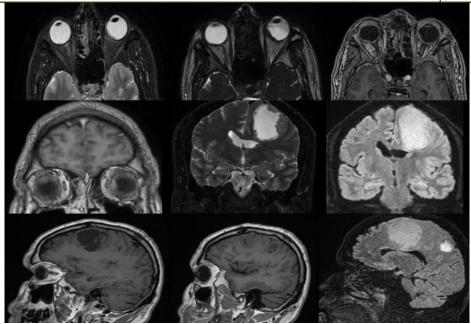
Craniorbital MRI: T1, T2, T1C+, T2*, FLAIR, and diffusion sequences in axial, coronal, and sagittal sections
